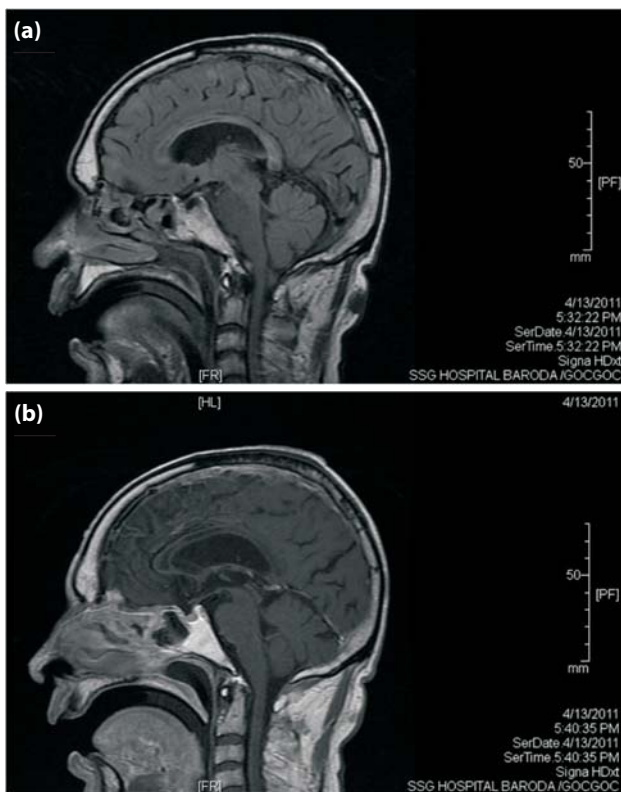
Sagittal MRI showing lesion in the body of corpus callosum which is hypointense on T1 image (a) and hyperintense on T2 image (b). Sandwich sign is positive.
